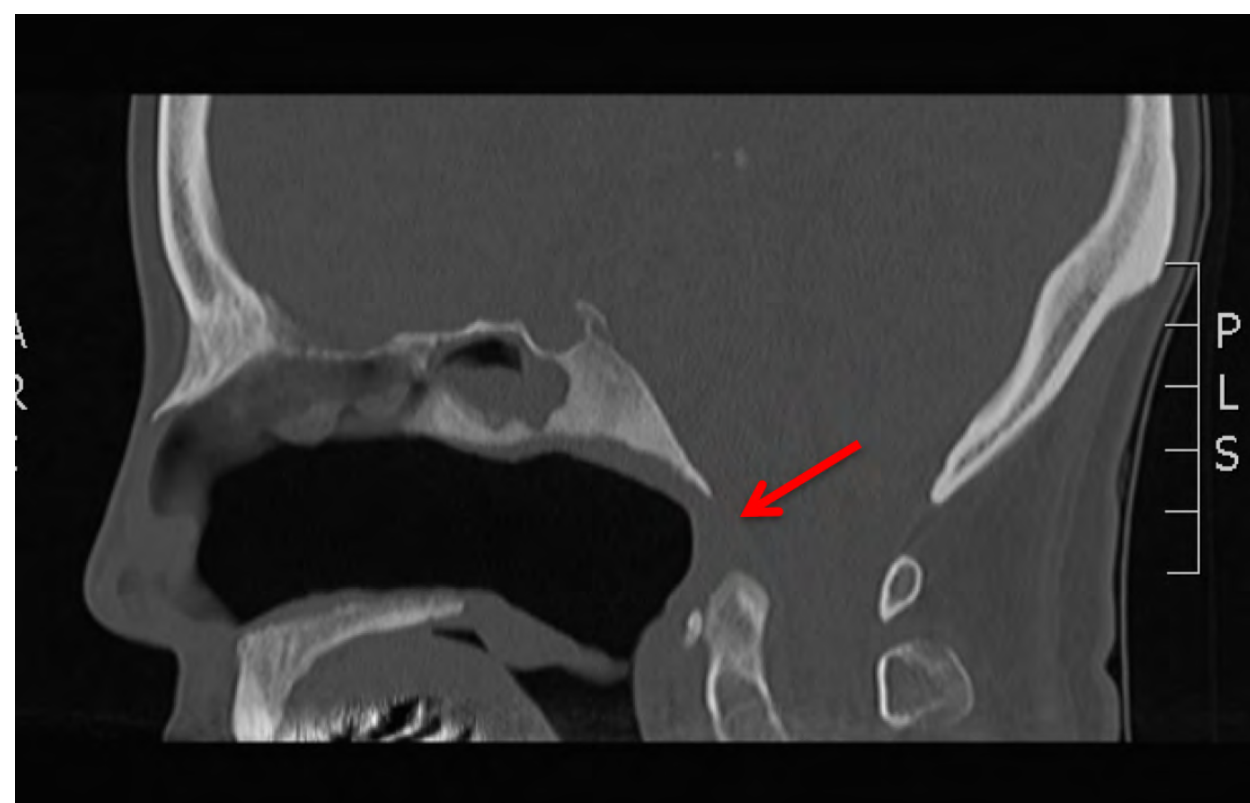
Sagittal CT demonstrates nasopharyngeal defect.
